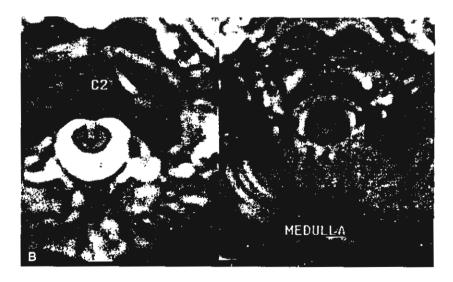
(B) Axial T1-weighted MRI with gadolinium. Enhanced lesions at the level of cervical cord and medulla in a paralytic rabies patient. (Courtesy of Dr. Jiraporn Laothamatas, Ramathibodi Hospital, Bangkok, Thailand.)
